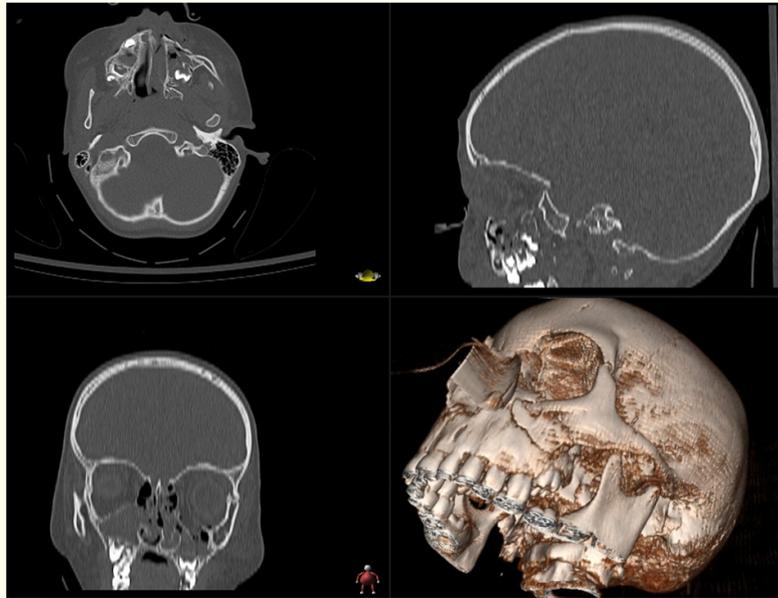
Caption: Axial, sagittal, coronal and three-dimensional views of the CT scan taken post trauma.
